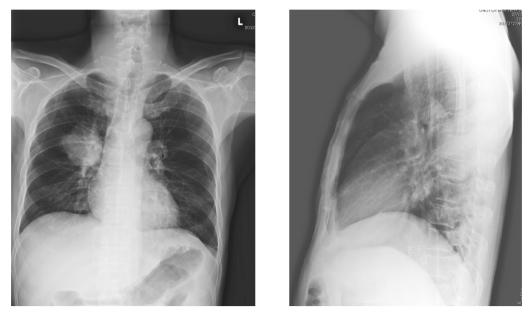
Chest radiograph on day 3 of hospitalization showing a round circumscribed opacity in the superior segment of right lower lobe.
